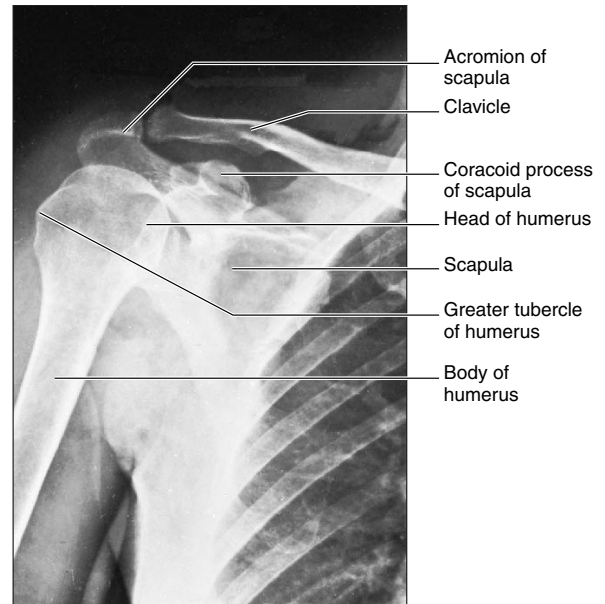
This radiograph of the right shoulder shows the positions of the clavicle, scapula, and humerus.
